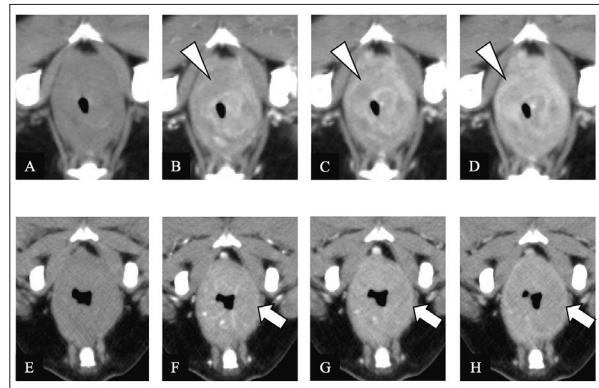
Representative CT images of rectal neoplasms forming a wall thickening lesion. CT images of adenocarcinoma in pre-contrast (A), arterial-phase post-contrast (B), portal-phase post-contrast (C), and equilibrium-phase post-contrast (D) images; and CT images of lymphomas in pre-contrast (E), arterial-phase post-contrast (F), portal-phase post-contrast (G), and equilibrium-phase post-contrast (H) images. Adenocarcinomas show a two-layered thickened annular bowel wall with heterogeneous enhancement (arrowhead). Lymphomas show a thickened annular bowel wall with homogeneous enhancement (arrow).
